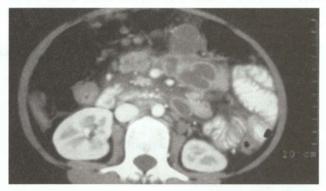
CT scan showing multiple enlarged lymph nodes with central necrosis in para-aortic and mesenteric region in abdominal tuberculosis
